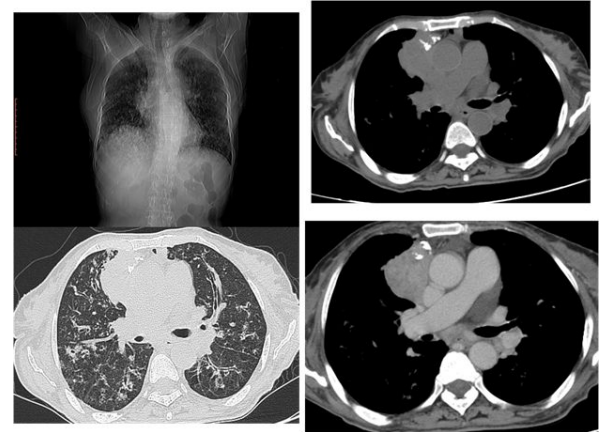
Patient 9: 74F- Thymoma AB with Goods syndrome: well defined homogenously enhancing mass with calcification. HRCT image of lung shows infiltration and bronchiectasis
